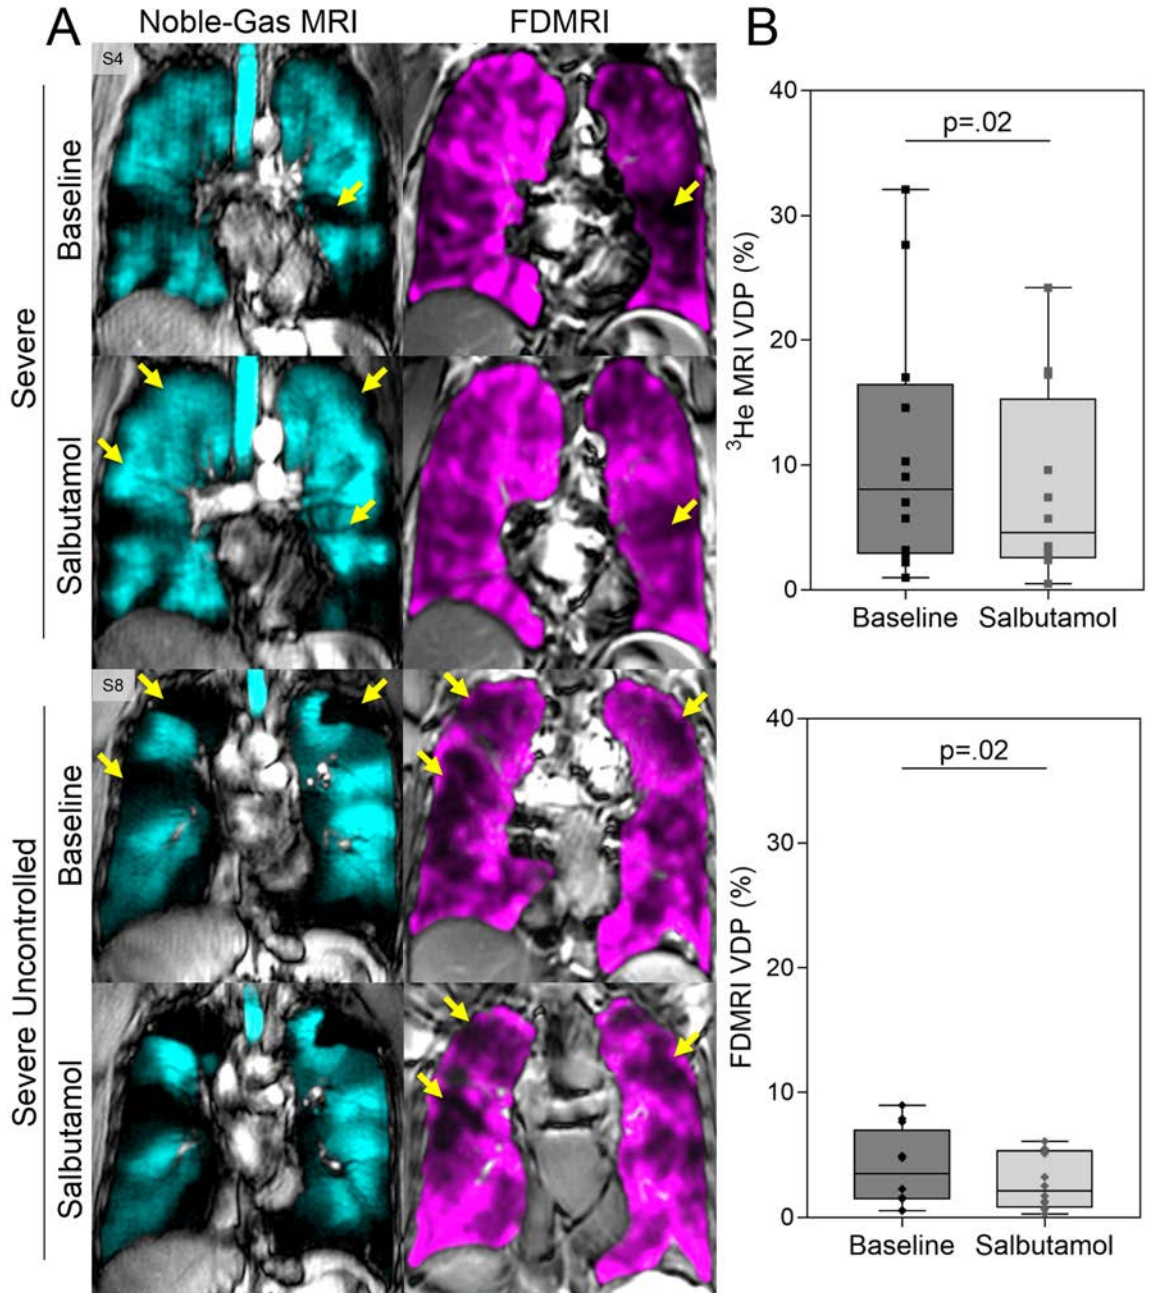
Ventilation MRI for severe and severe-uncontrolled asthmatics
